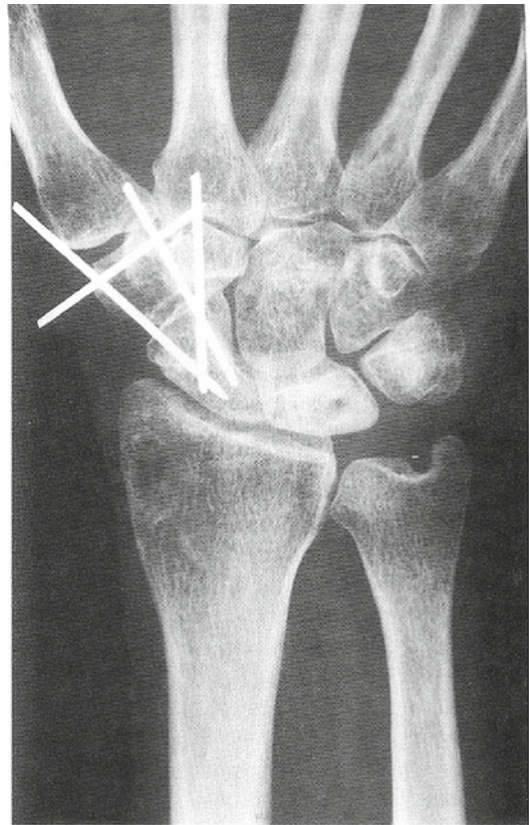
Postoperative PA radiograph of a 46-year-old woman who underwent temporary STT pinning for treatment of stage IIIa Kienböck's disease. Reprinted from *Journal of Hand Surgery*, 23(3), Yajima H, Ono H, Tamai S, Temporary internal fixation of the scaphotrapezoid joint for the treatment of Kienböck's disease: a preliminary study, 402–410, Copyright 1998
